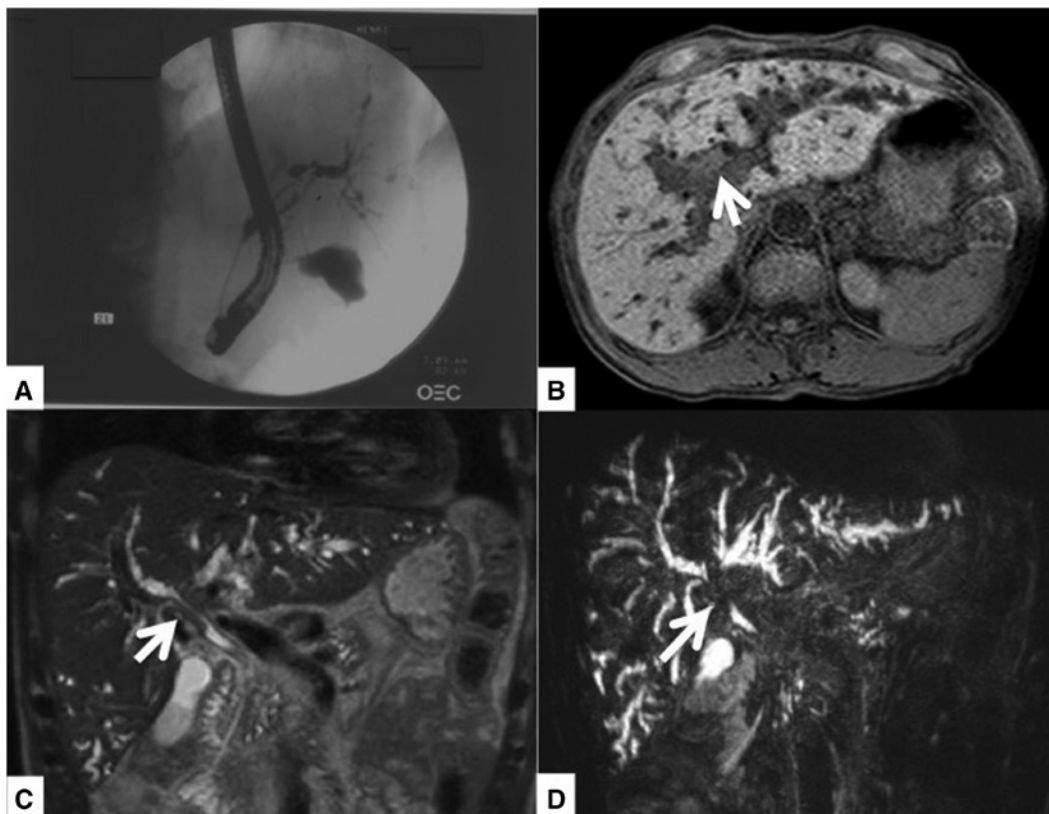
(A) ERCP; (B) (transversal), (C, D) (both frontal): MRI.
